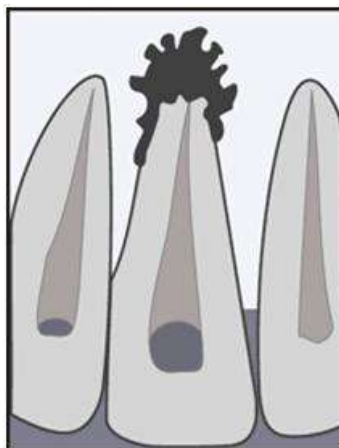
Scheme of periapical abscess with sinus
